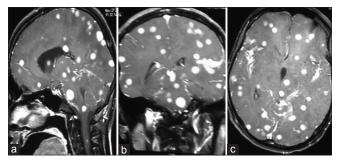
Magnetic resonance imaging brain T₁-contrast imaging showing multi-lobar tuberculomas diffusely enhancing with contrast. Sagittal, coronal, and axial contrast images revealing homogenous enhancing lesions (a-c respectively)
